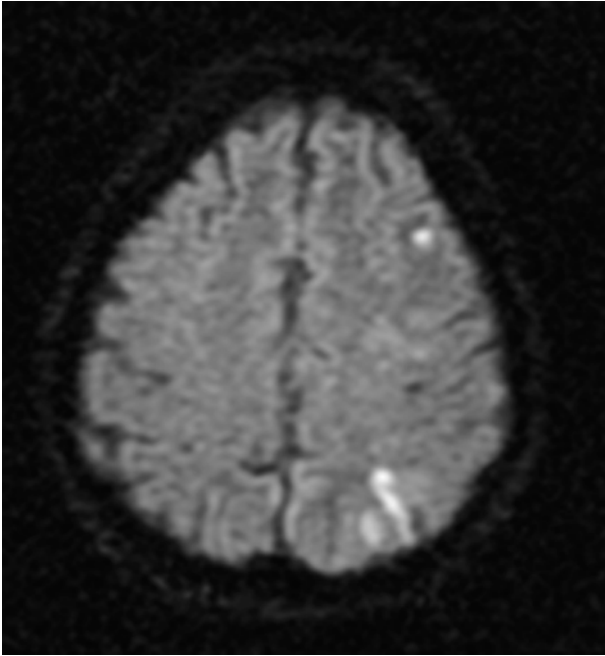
Diffusion MRI demonstrates several small acute infarcts in the left MCA territory. Distribution is suggestive of embolic disease.
